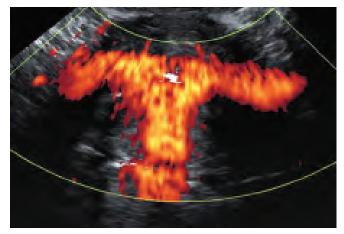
Saline infusion hysterosalpingography under power Doppler control shows easy passage of the fluid through both fallopian tubes
